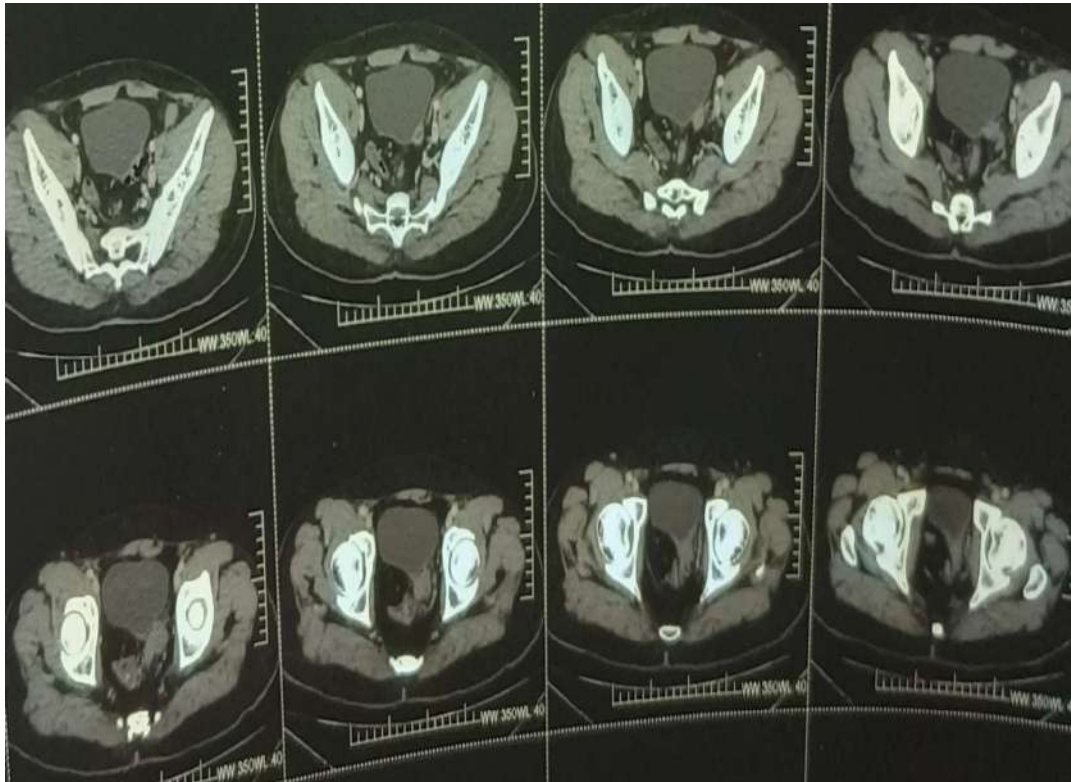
Serial axial sections of CT scan of the patient showing adherent rectosigmoid junction adherent to the left posterolateral wall of bladder.
